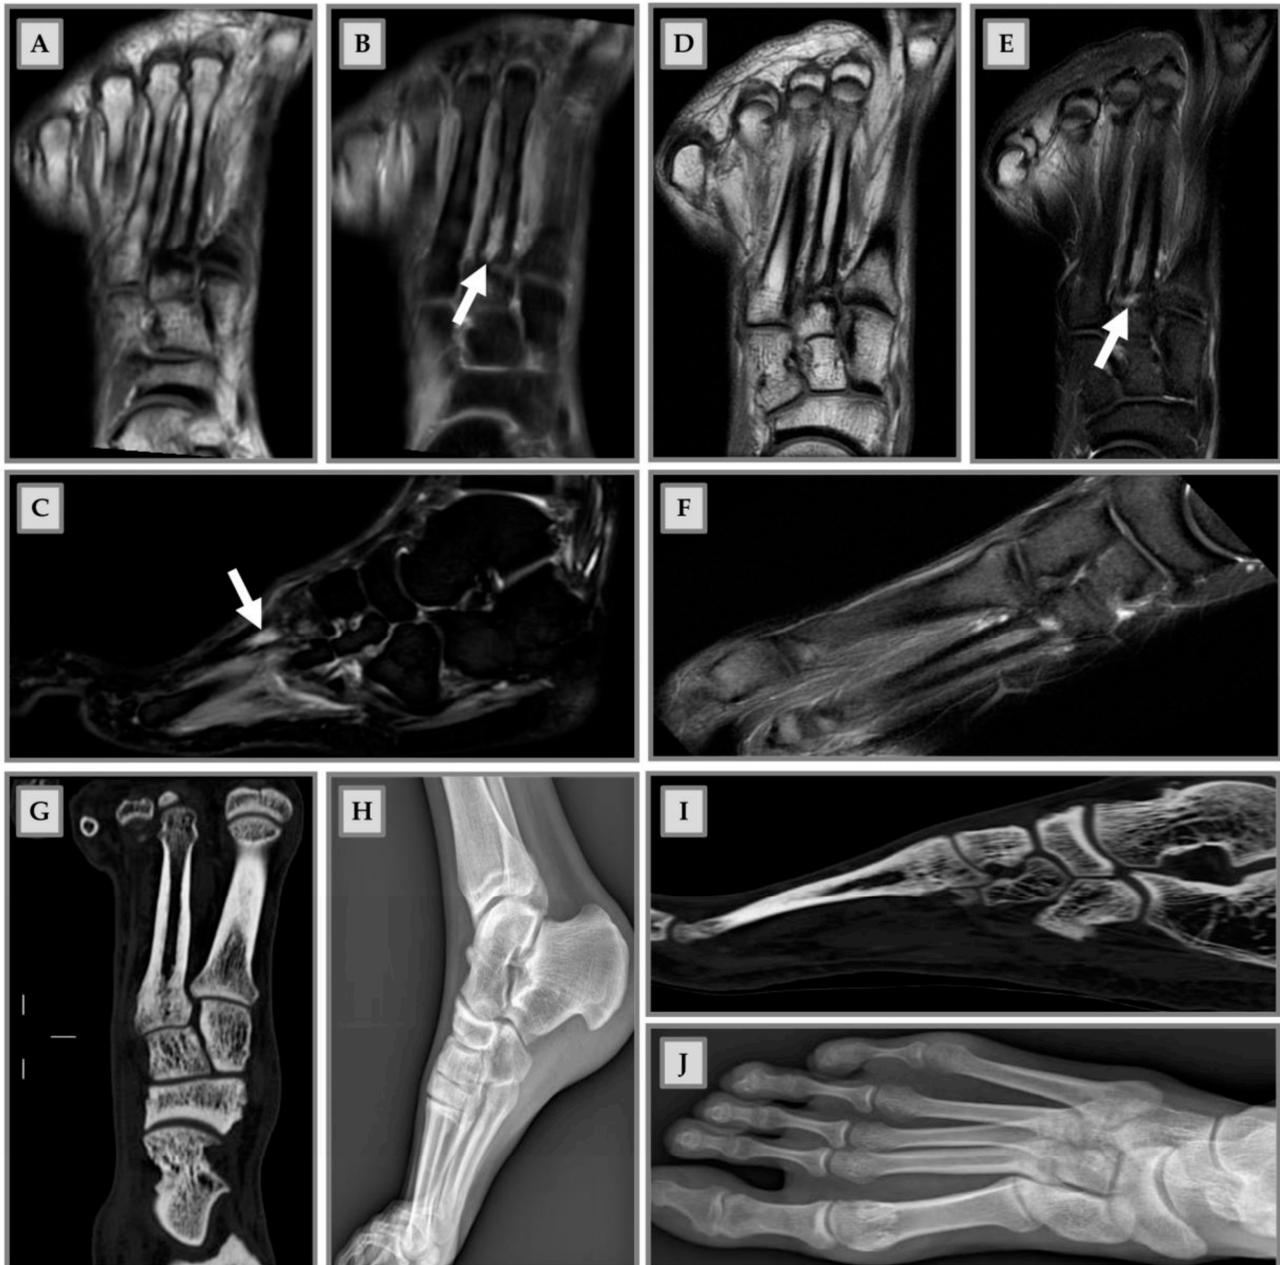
Male patient, 22 years old, professional rugby player. (A–C): Stress fracture of II metatarsal base; (B,C,E): altered signal intensity, hyperintense in short-tau inversion recovery (STIR), related to BME (arrows); (D–F): MRI check after 3 months: advanced fracture healing process and pain release; (G,H): CT check at 6 months after therapy. Fracture healing, pain release and sport restart; (I–J): radiography check at 9 months after therapy and 1 month of sports activity. Patient recovery.
